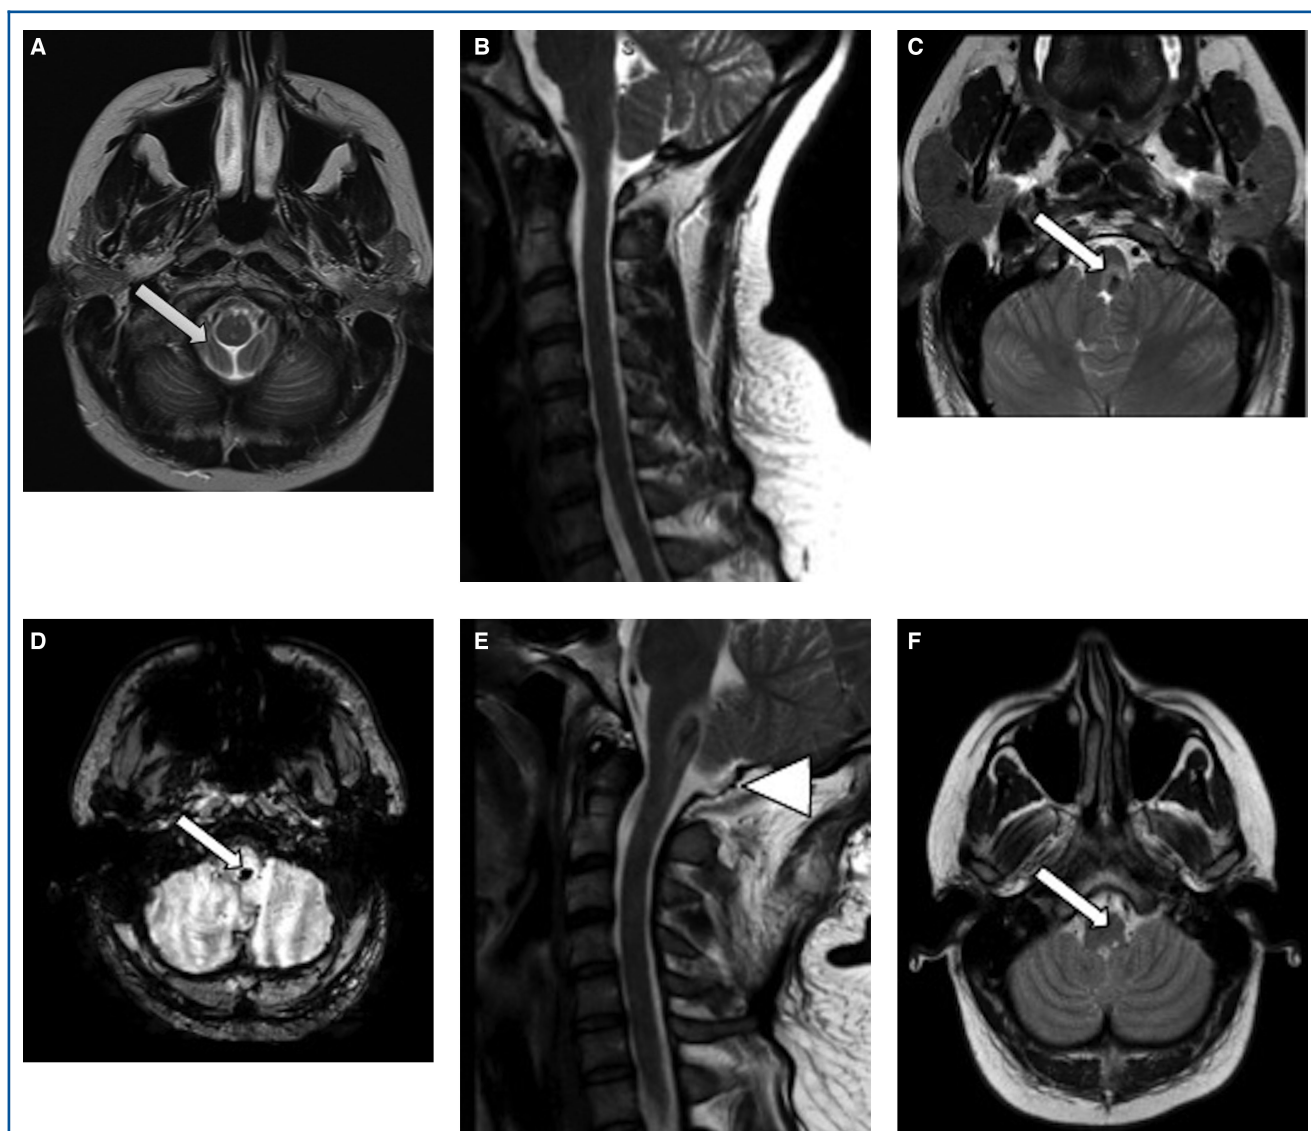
Case 2. A and B, Preoperative T2-MRI axial and sagittal section highlighting ectopic cerebellar tonsil (arrow, A) resulting in crowding of foramen magnum. Immediate postoperative MRI T2 axial C, SWI D, and sagittal E slices with left-side acute medulla hemorrhage (arrows in C and D) with successful tonsillar decompression (arrow head, E). Follow-up MRI T2 axial F section showing resolution of hemorrhage (arrow).
